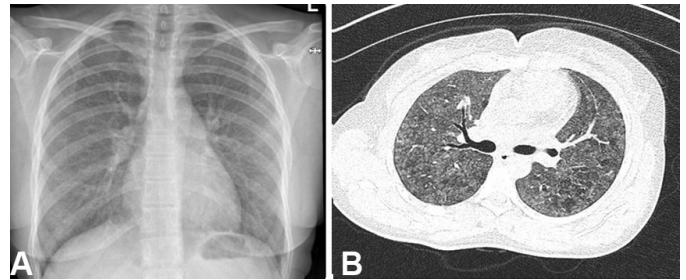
(A) Chest radiograph showing bilateral interstitial shadowing. (B) CT scan showing extensive centrilobular ground glass shadowing with evidence of air trapping and in keeping with a hypersensitivity pneumonitis.
